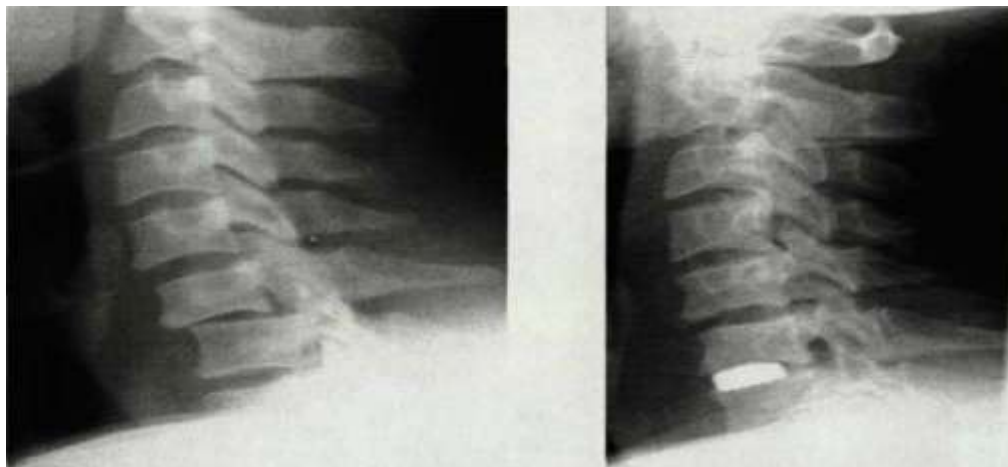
X-ray picture of patient G.: a - before surgery; b - 12 months after the operation.
